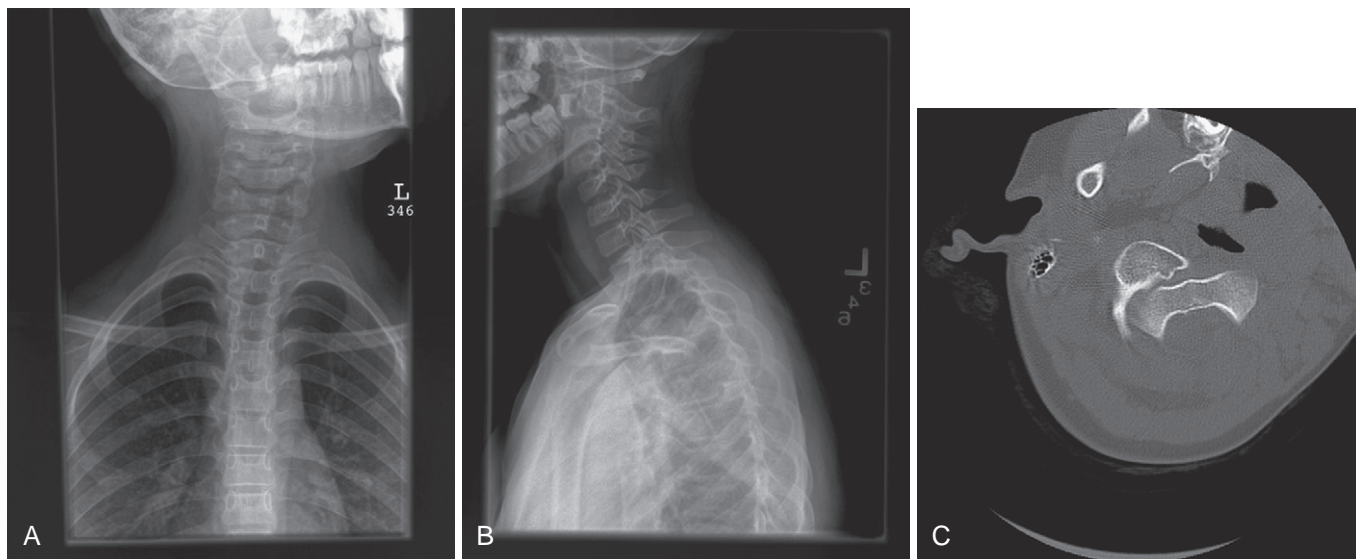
An example of C1-C2 rotatory subluxation. The patient is a 9-year-old girl with painful torticollis for 3 months after a motor vehicle accident. Anteroposterior (AP) (A) and lateral (B) cervical spine radiographs confirm torticollis; however, bony details and relationships are obscured at the cranio-cervical junction. C, Axial computed tomography (CT) shows the right C1 lateral mass dislocated and rotated clockwise relative to C2, which is diagnostic of C1-C2 rotatory subluxation.
